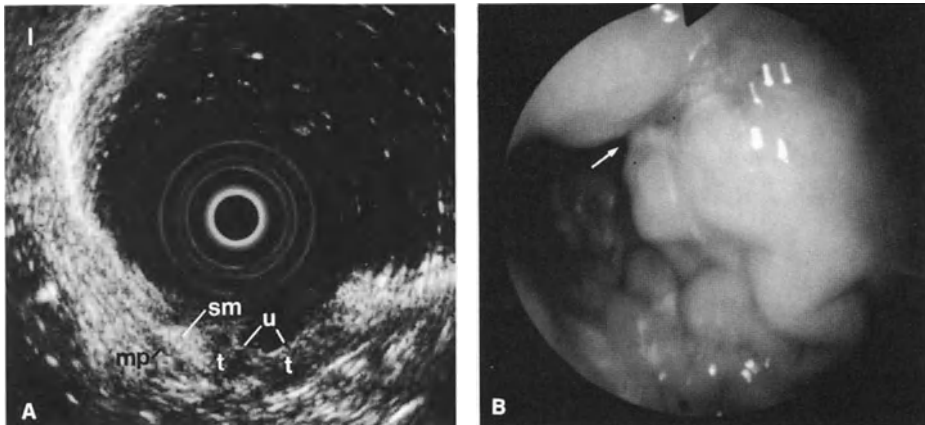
A Endoscopic sonogram showing hypoechoic tumor (*t*) infiltration into the submucosal layer (*sm*), penetrating into the muscularis propria (*mp*) directly adjacent to the ulcer (*u*). *l*, liver. B Corresponding endoscopic image, showing the ulcer (*arrow*) with nodular margins
